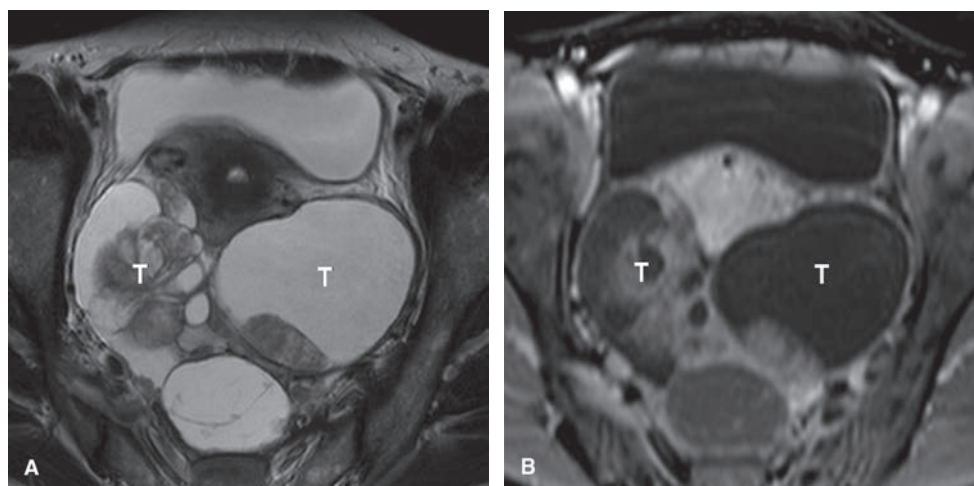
Ovarian carcinoma. Axial T2W FSE (A) and T1W contrast-enhanced fat-saturated (B) MR images show bilateral solid and cystic adnexal masses (T in A, B). Note the avid enhancement of solid components (B) after administration of intravenous gadolinium.
